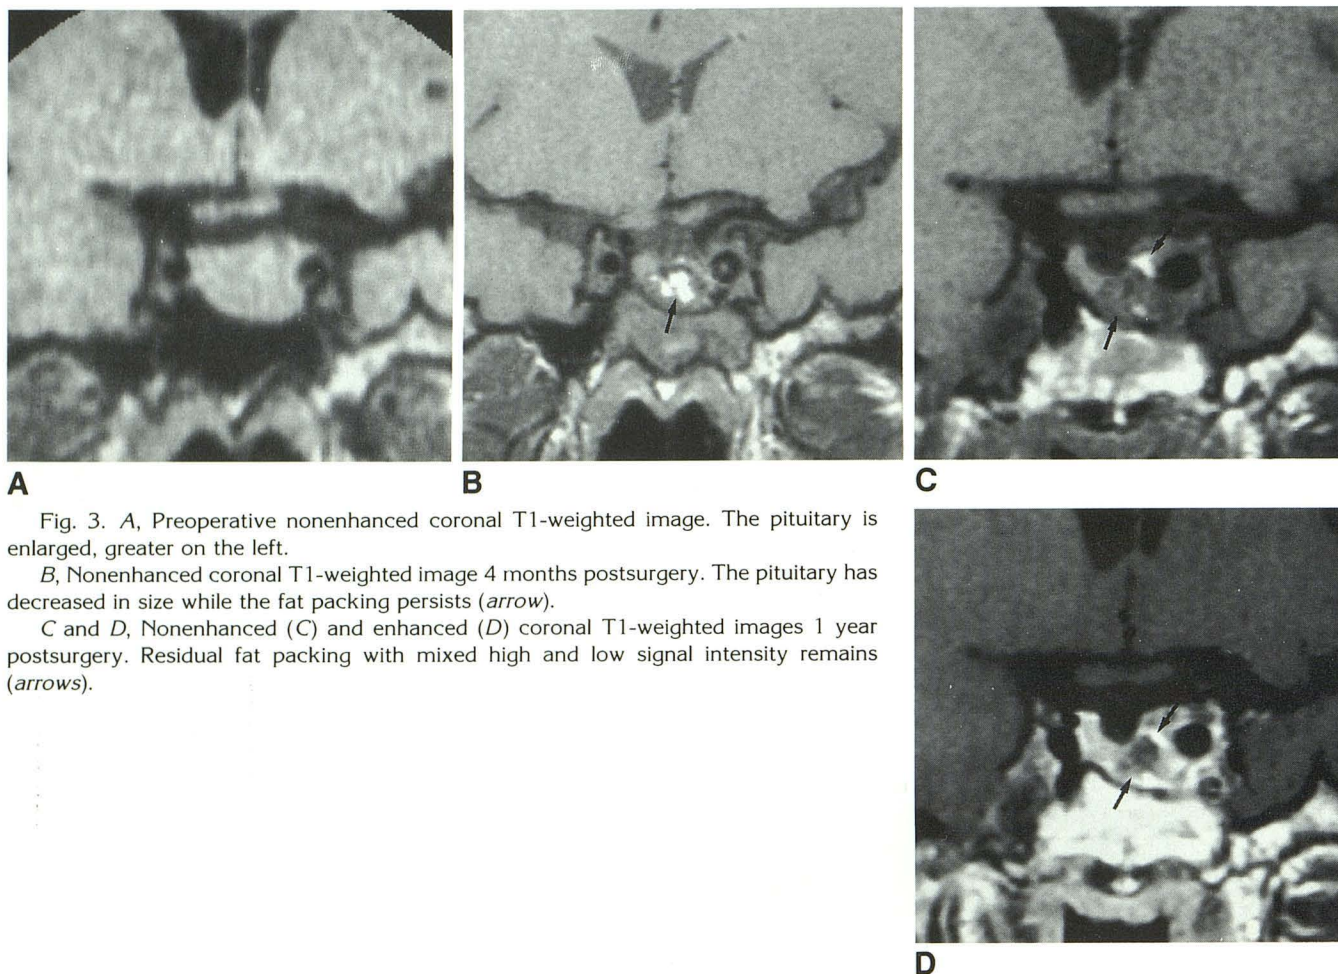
A, Preoperative nonenhanced coronal T1-weighted image. The pituitary is enlarged, greater on the left.
